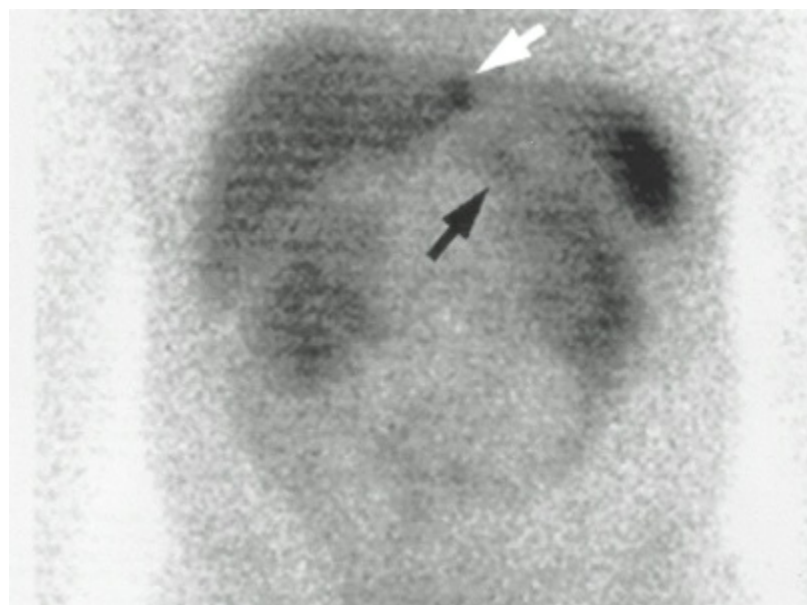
Somatostatin receptor scintigraphy in a patient with multiple endocrine neoplasia type I. This scintiscan detected an otherwise unrecognized metastasis to the left lateral segment of the liver (*white arrow*), which was resected along with the small primary tumor (*black arrow*).
